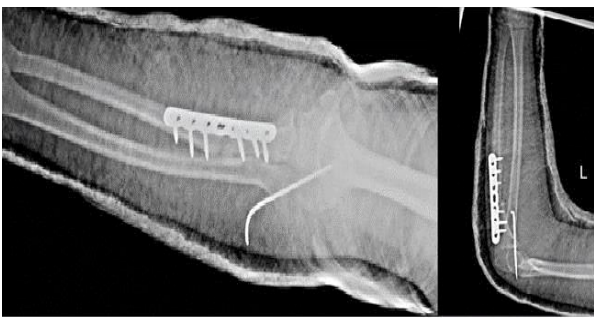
Post-operation x-ray of left elbow, Limited Contact Dynamic Compression Plate (LC-DCP) applied for internal fixation of ulna; radio-capitellar pin was used to fix radial head, patient's arm was cast at 90° flexion
